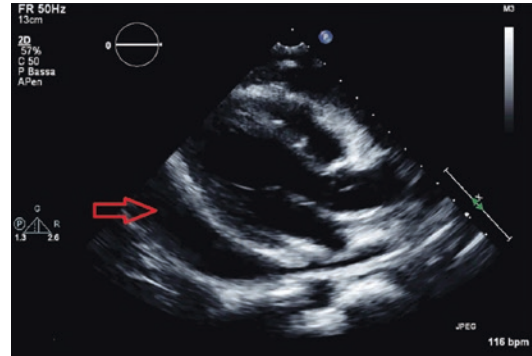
Echocardiographic findings in acute pericarditis. The red arrow indicates a large circumferential pericardial effusion
